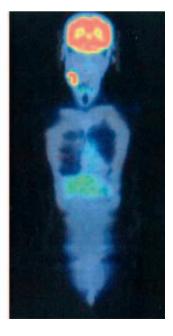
PET-CT revealed a coarse mass of SUVmax 12 in the right neck but no other significant mass.
